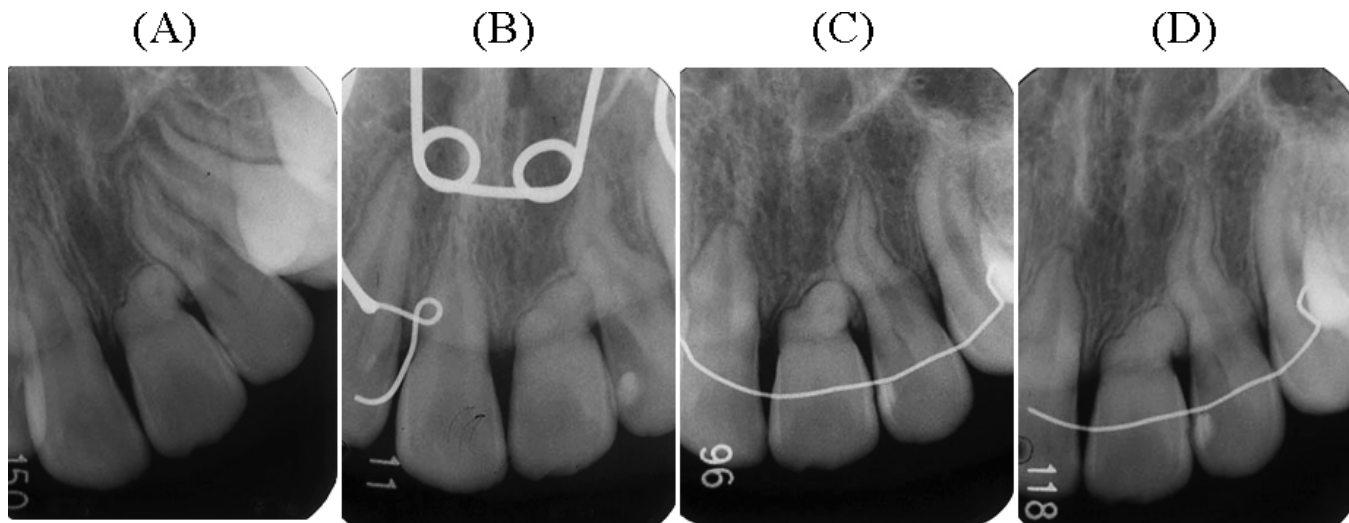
Periapical radiographs of maxillary incisors through orthodontic treatment.(A) Before treatment. (B) After lateral expansion. (C) Immediately after treatment. (D) Three year after retention.
